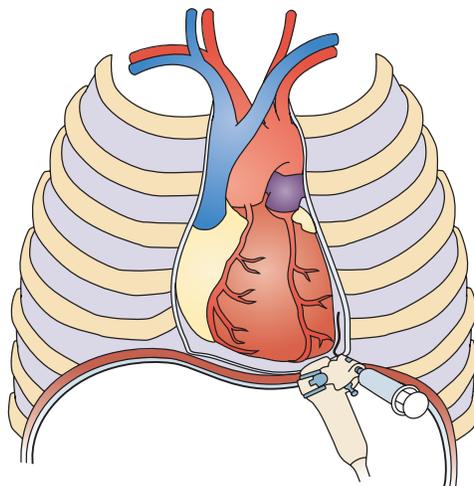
Representation of pericardiocentesis using the apical approach. The pericardial needle is continuously monitored by apical four-chamber echocardiographic view while entering the pericardial space. When the pericardial effusion is reached, a guidewire is introduced in the pericardial space.
